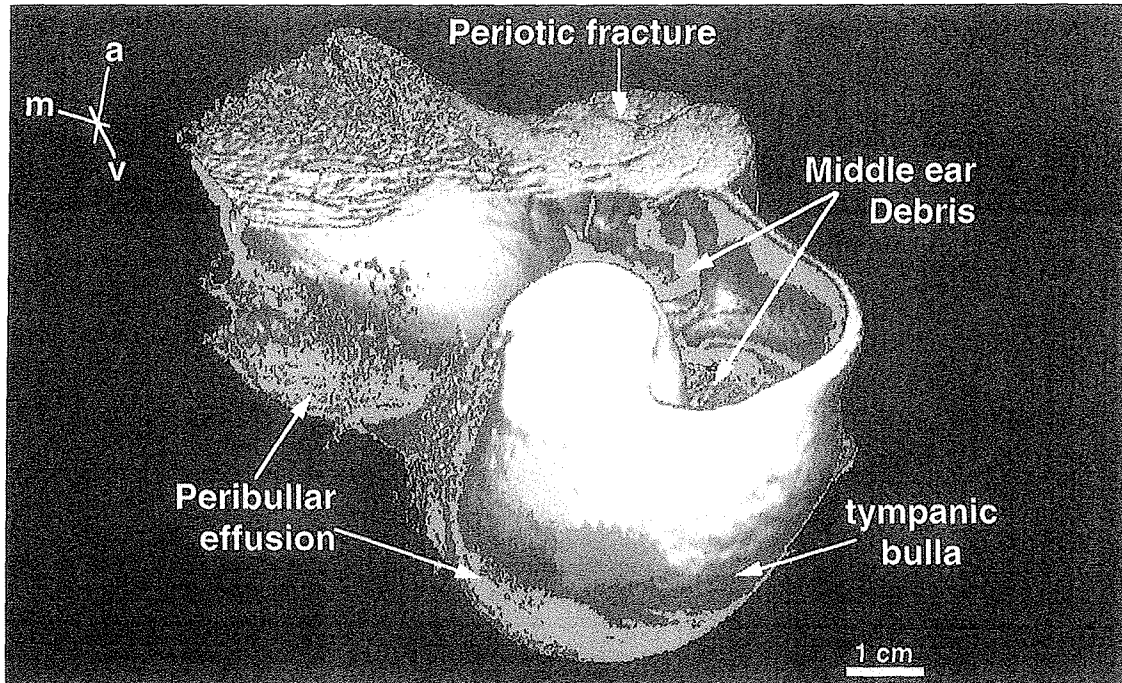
A three-dimensional reconstruction from CT scans of an ear from a humpback whale (*Megaptera novaeangliae*) with blast injuries shows multiple fractures throughout the periotic, which are consistent with intracochlear blood. Blood, serum, and cellular debris of both intra- and extra-cochlear origin filled the middle ear and surrounding peribullar region (reproduced with permission, Ketten *et al.*, 1993).
